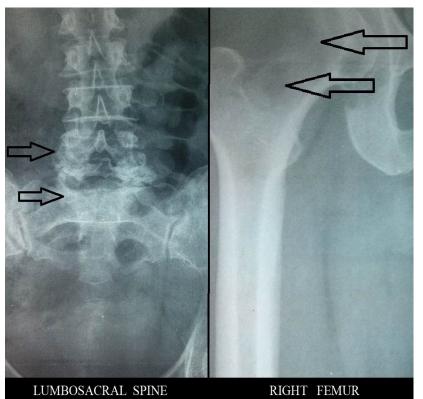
Radiograph of lumbosacral spine and right femur showing lytic lesions on the sacrum, L5 vertebrae, head and neck of femur.
